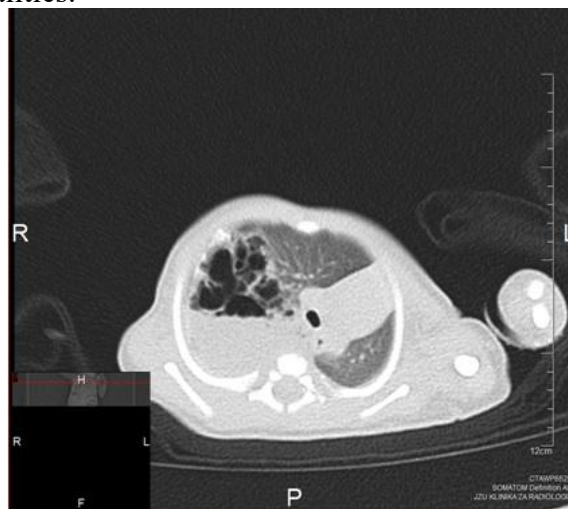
Chest CT scan - right congenital cystic adenomatous malformation
